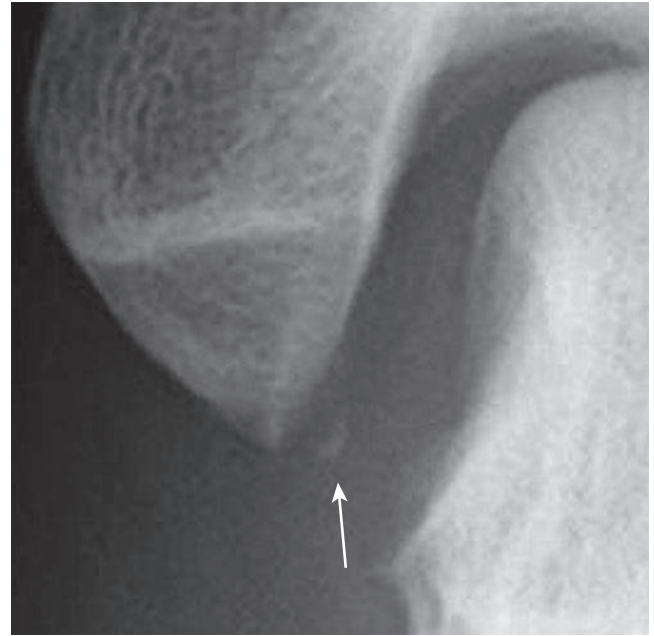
Radiographic example of small avulsion of deltoid ligament with widened medial clear space. Arrow denotes the small bony avulsion. (Courtesy Thomas O. Clanton, MD)
